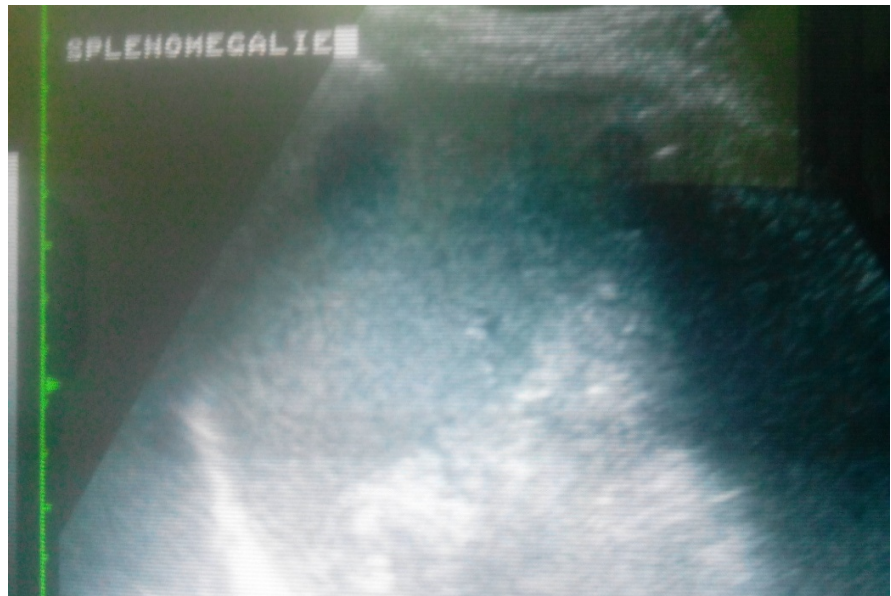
Ultrasound showing splenomegaly in our HCV+ patient.
